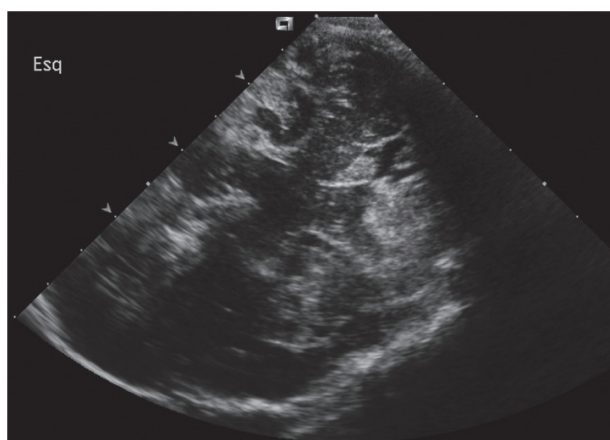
Cerebral ultrasound showing left cerebellar hemorrhage.
